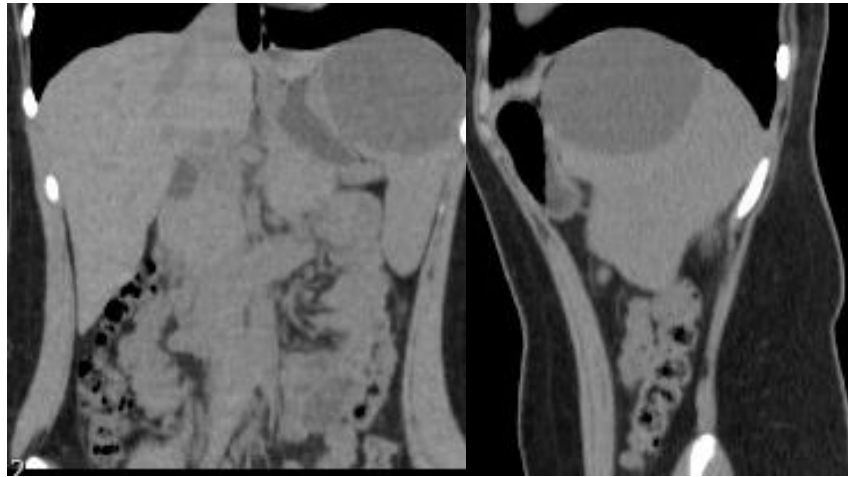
MRI In the area of the upper half of the spleen, a parenchymal cyst, with dense contents, encapsulated, diameter 85x72x90mm
